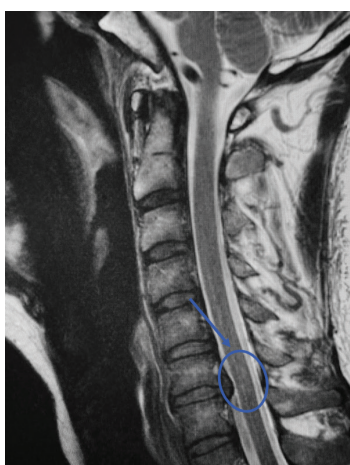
Magnetic Resonance Imaging -Mid-Sagittal Image of the lesion on the C6-T1 Spinal Cord with the use of gadolinium contrast
